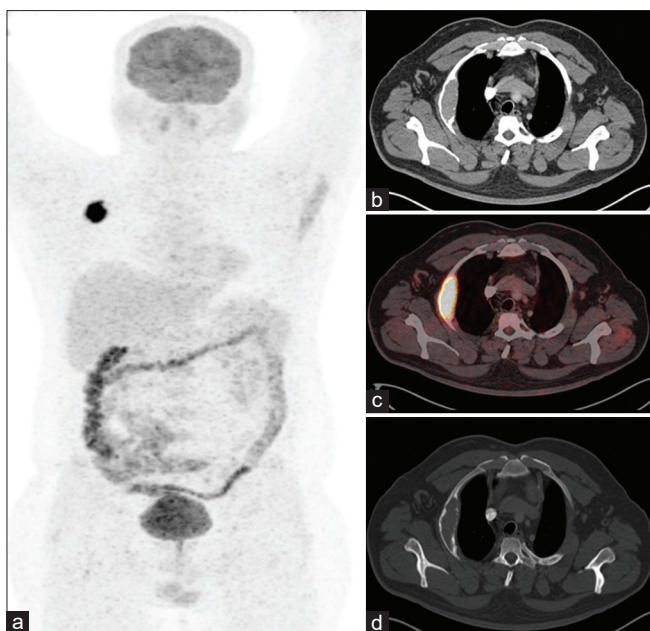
(a) Maximum intensity projection of 18F-fluorodeoxyglucose positron emission tomography/computed tomography, (b) Lesion in computed tomography, (c) Lesion in positron emission tomography/computed tomography and (d), Lesion in computed tomography (bone window)
